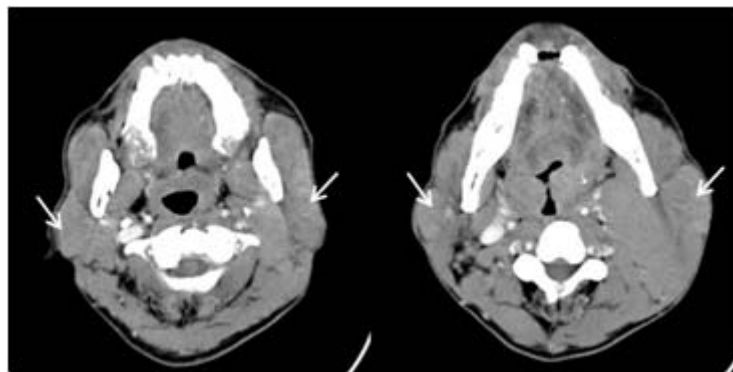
Parotid NHL. Enhancing axial CT scan showed bilateral parotid glands enlargement (arrow), lesions at bilateral palatine tonsils and lingual tonsil and multiple matted cervical lymphadenopathy. There was splenomegaly (not shown) on abdominal CT scan.
